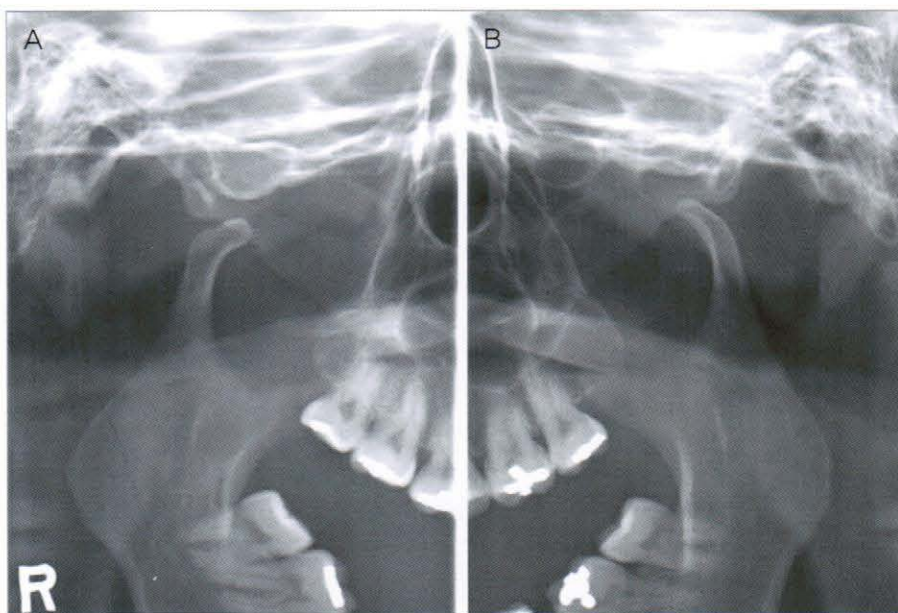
Pre-treatment TMJ panoramic radiograph (2006, 9.4)
